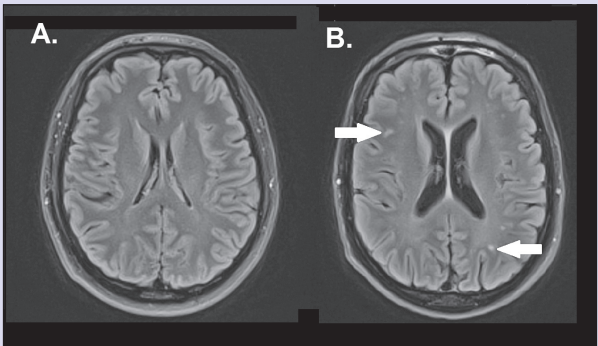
MRI of brain in two people of similar ages, one with a diagnosis of myotonic dystrophy (B) and one without (A). Scan B shows some widening of the dark, fluid-filled spaces in the centre of the brain, indicating loss of brain volume. In addition, changes affecting the white matter (marked with arrows) are seen more frequently in the affected person.
